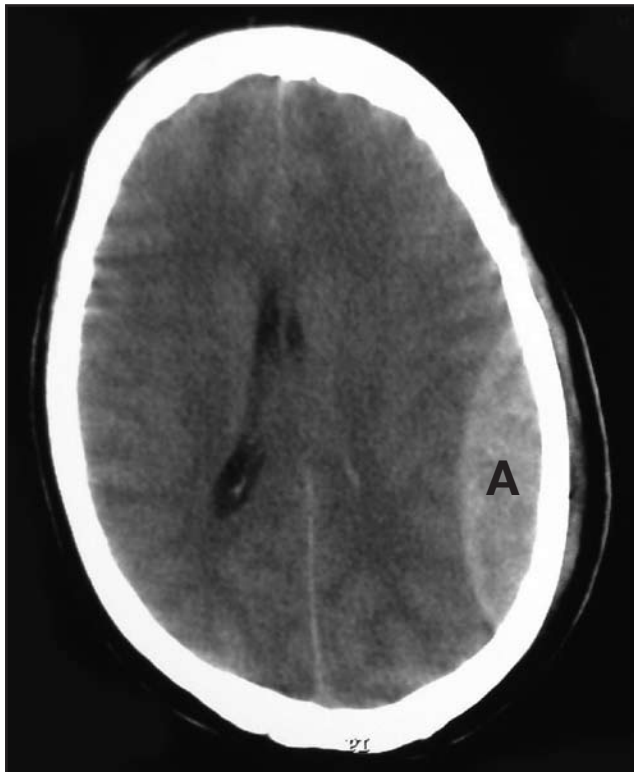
An extradural haematoma (A) on a CT scan
